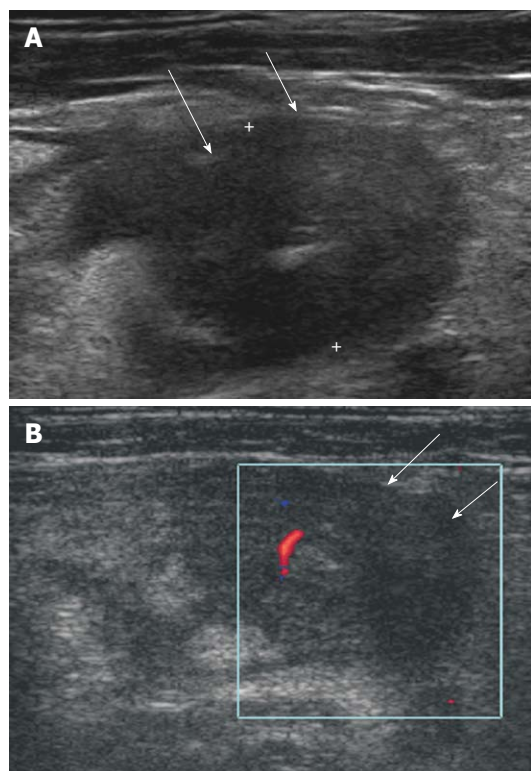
Isolated Crohn's appendicitis. A: Marked thickening with transverse hypoechoic echo-alteration of appendiceal wall (arrows); B: Mild increased blood flow in thickened appendiceal wall (arrows) was seen on color Doppler study.
